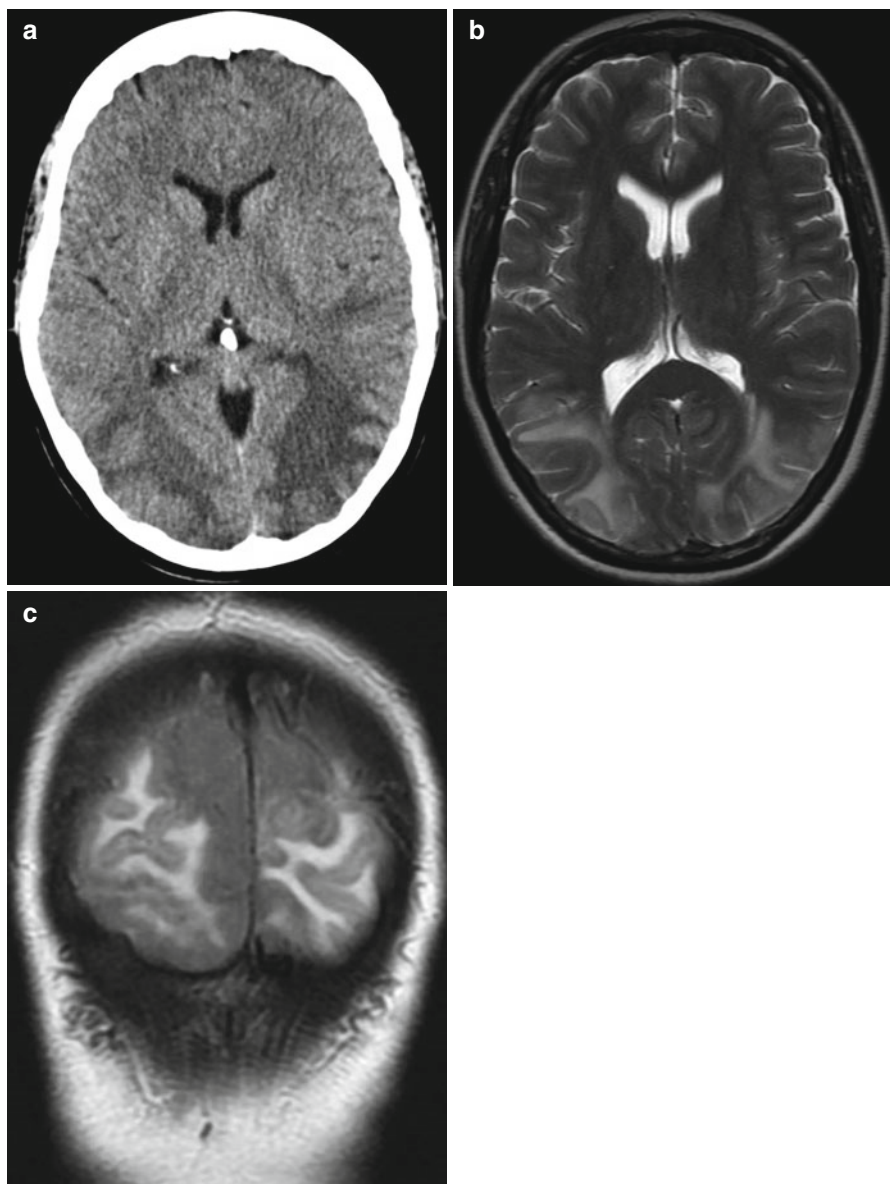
Posterior reversible encephalopathy syndrome. (a) CT demonstrates bilateral areas of cortical and subcortical low attenuation in occipital lobes; corresponding T2-weighted (b) and coronal FLAIR (c) images of the most typical distribution
